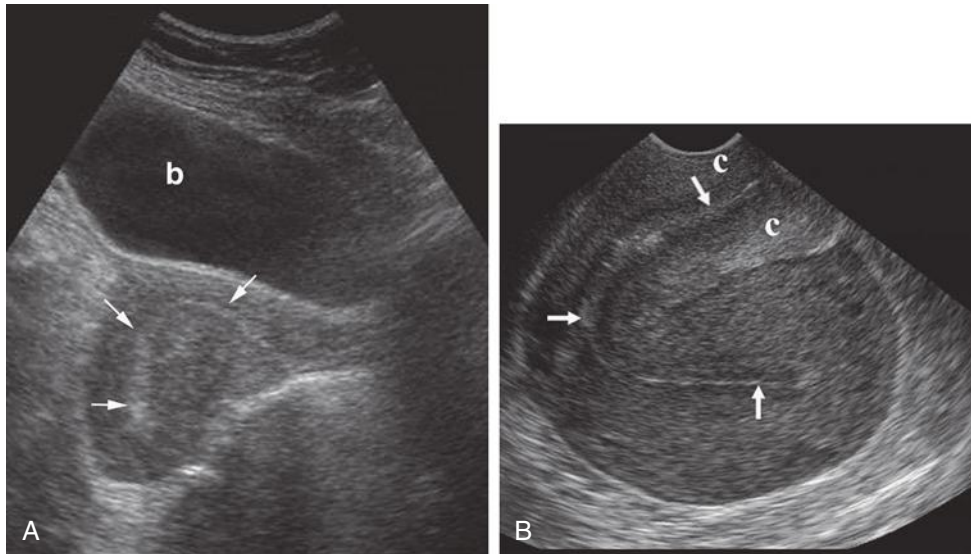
Retroflexed uterus. Transabdominal (A) and transvaginal (B) sonograms of a retroflexed uterus. The uterine body is bent backward or posteriorly at the level of the internal os of the cervix (c), well over 90 degrees. On the transabdominal image, the cervix is tilted upward with respect to the vagina, indicating anteversion. In B, when the bladder is emptied to perform the transvaginal examination, the cervix points slightly posteriorly, indicating a change to retroversion. Note the endometrial and endocervical canals (arrows). b, bladder.
